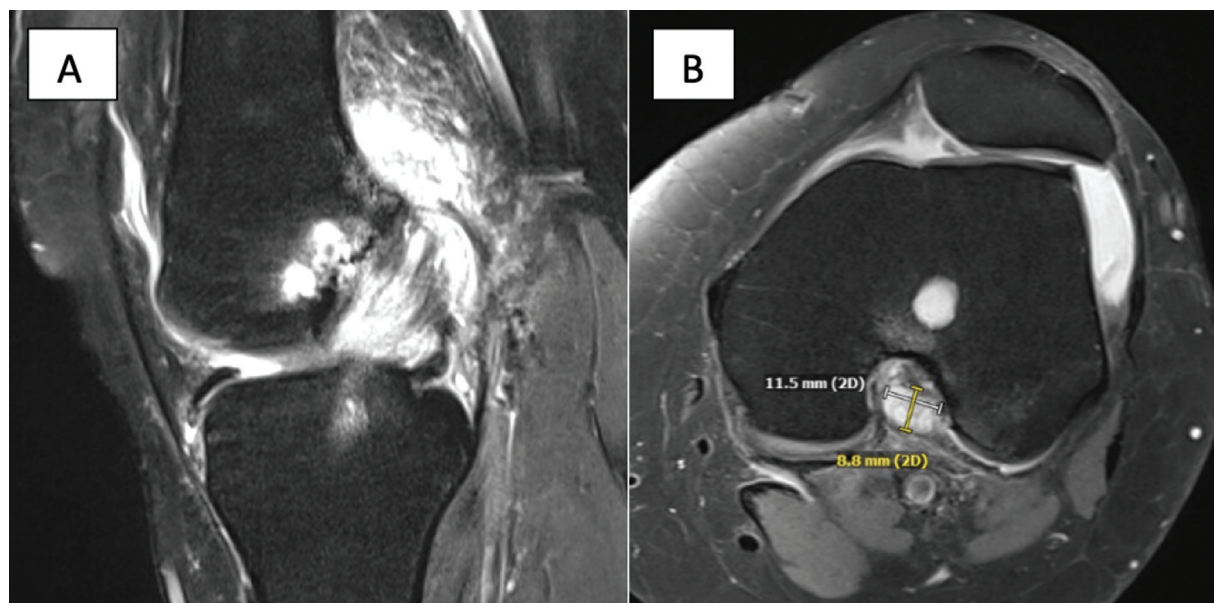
Mucooid degeneration of ACL. (A) MRI demonstrates parameniscal cyst and mucooid degeneration of the ACL seen on sagittal image with thickening of the ACL and increased signal. (B) Associated large posterior cyst that abuts the posterior femoral condyle and femur.
